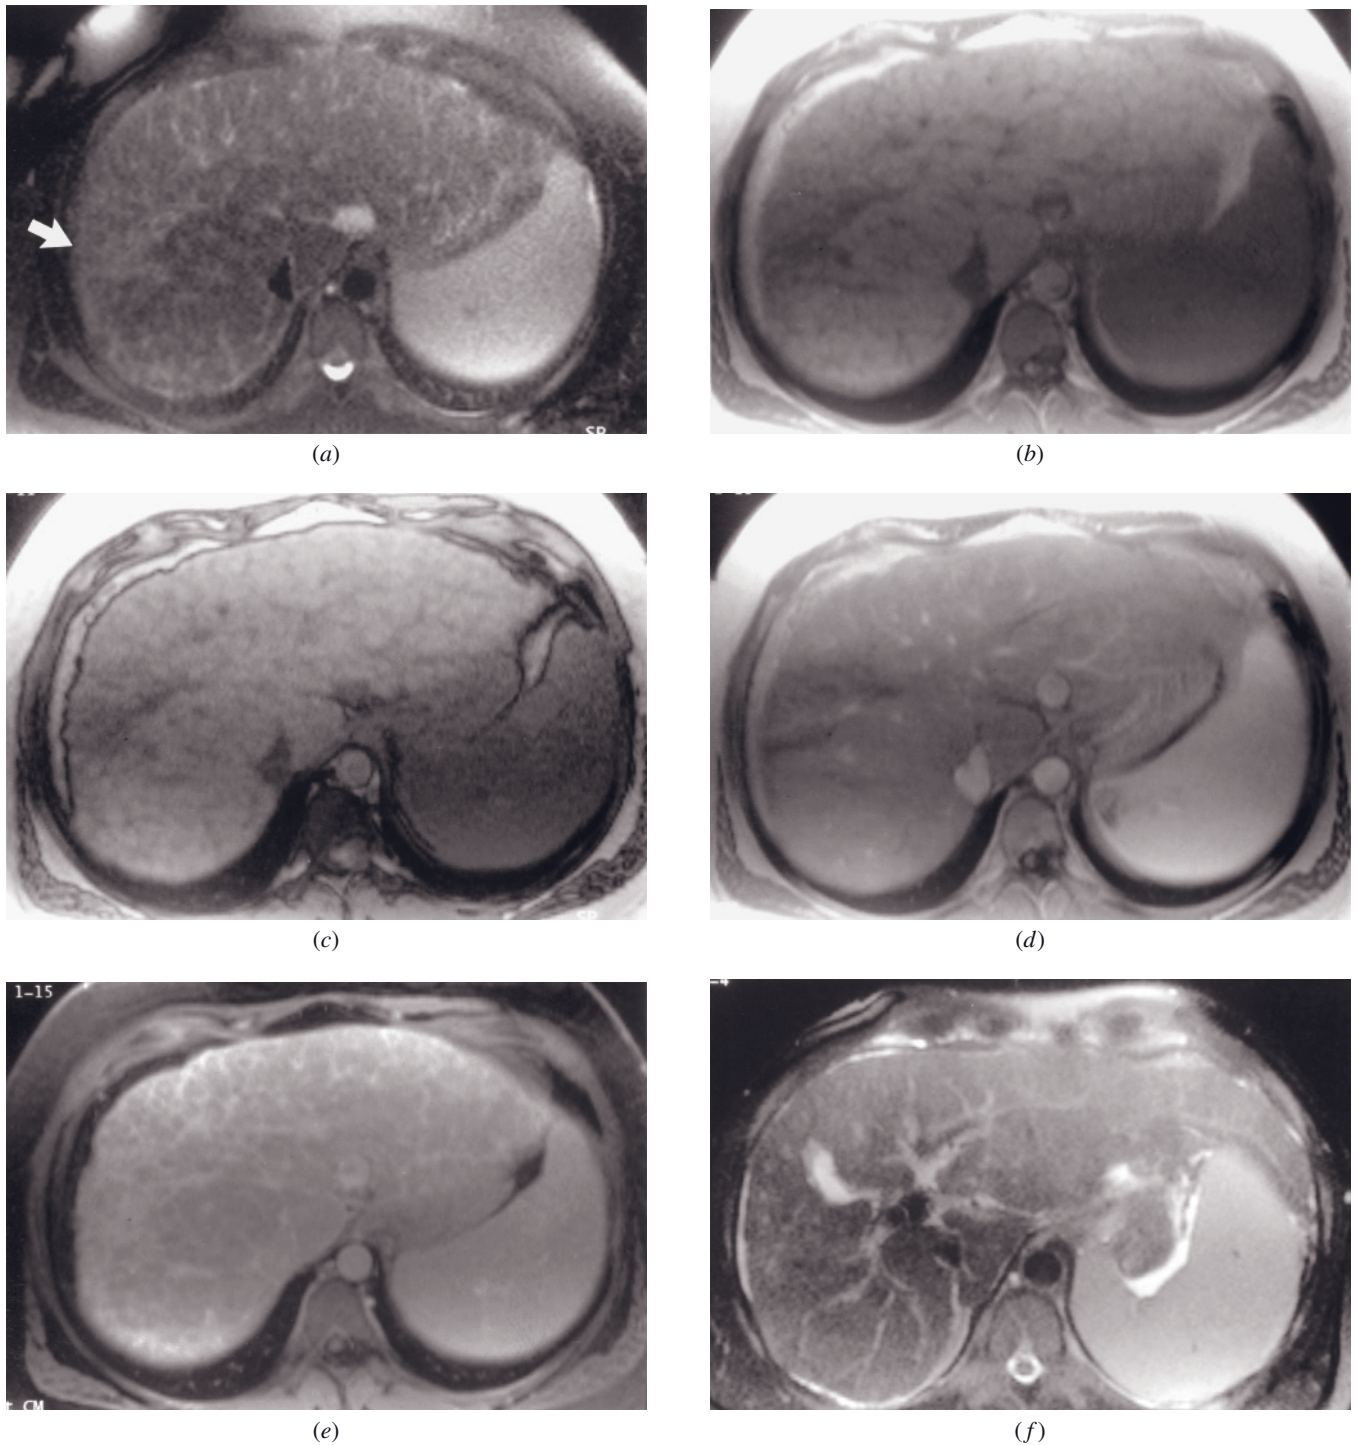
Cirrhosis with confluent fibrosis. Echo-train STIR (*a*), SGE (*b*), out-of-phase SGE (*c*), and immediate (*d*) and 90-s fat-suppressed (*e*) postgadolinium SGE images. There is a linear pattern of fibrosis throughout the liver, with a focal region of confluent fibrosis (arrow, *a*) that is mildly high in signal on T2 (*a*) and mildly low in signal on T1-weighted image (*b*) and demonstrates negligible enhancement on early postcontrast image (*d*) and mild enhancement on late image (*e*). Note that the fine pattern of fibrosis present throughout the liver is particularly well shown on the short TE out-of-phase image (*c*) as low-signal linear structures (*c*) and on late postgadolinium as linear enhancing structures (*e*).
